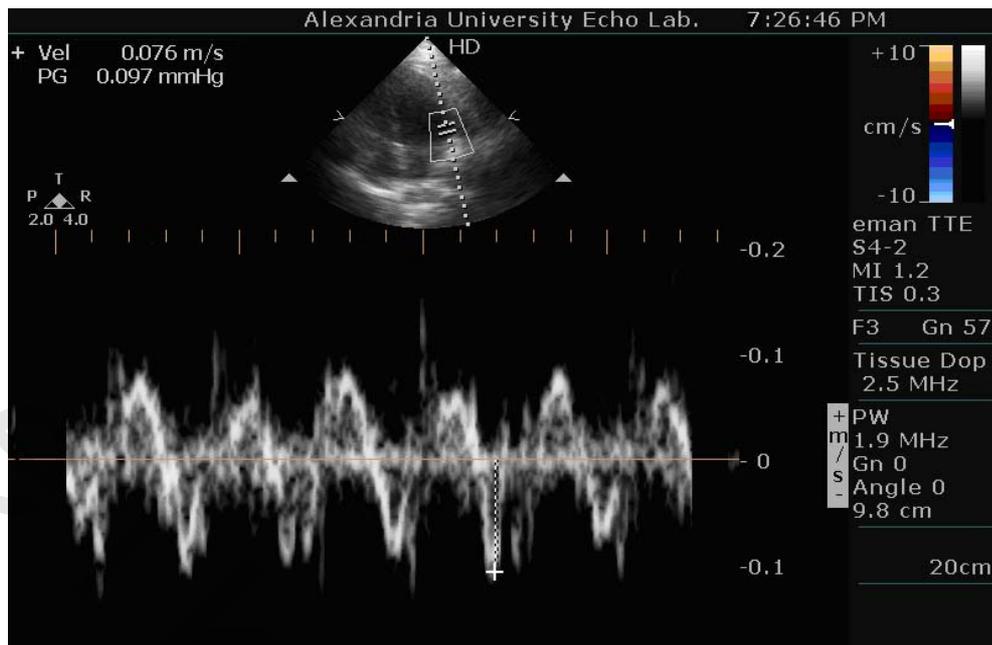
Tissue Doppler lateral mitral annular velocity after dialysis.
